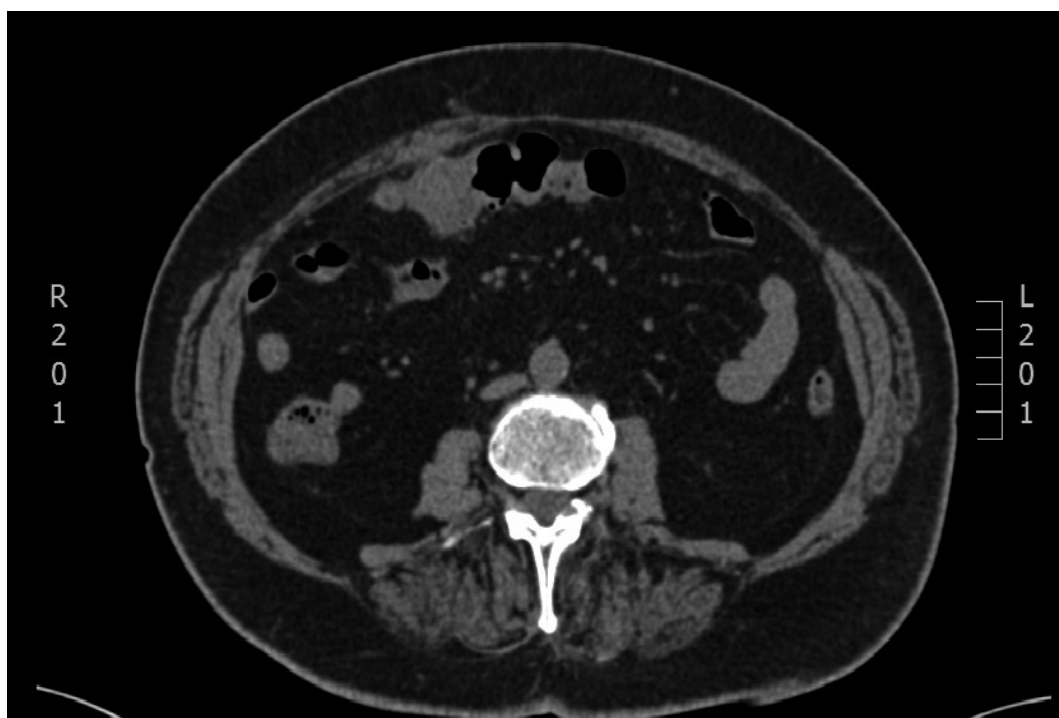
CT image of remission.
